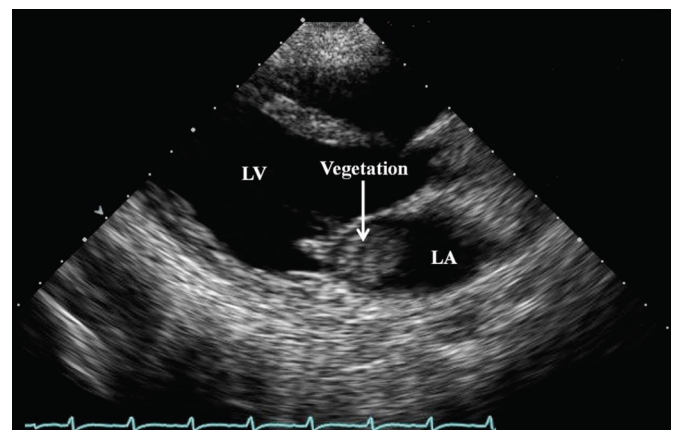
Preoperative echocardiographic finding of a large vegetation in the parasternal long-axis view. LA indicates left atrium; LV, left ventricle.
